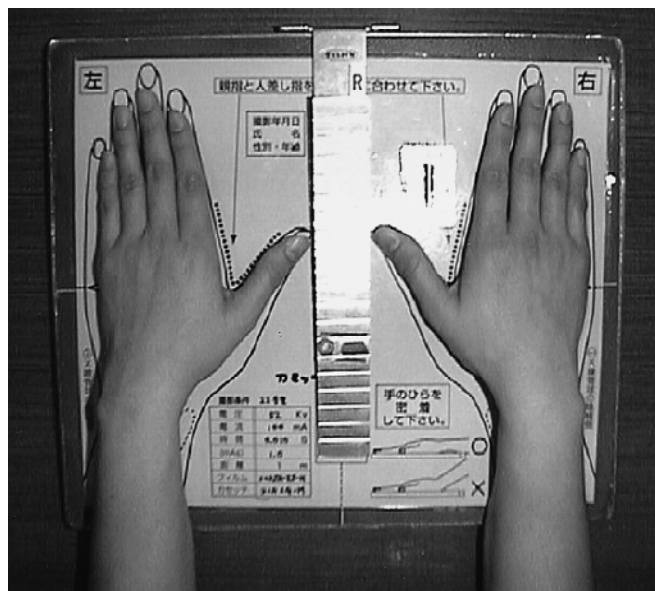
An anteroposterior radiograph of hands with an aluminum step wedge was taken so that the distal part of the forearm was included. The cubic image distance was 1 m, and the radiograph was taken with 52 kV, 100 mA, and for 0.01 s. A marker was attached on the seventh step of the aluminum step wedge
